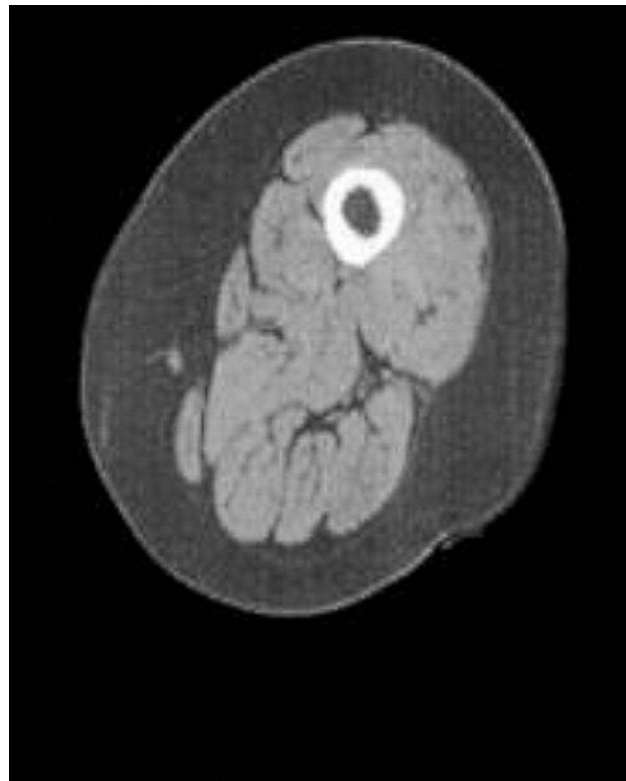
MRI of the same patient with moderate degree of obstruction, but evident sarcopenia. In the cross section of the subject's leg it is possible to notice a reduced muscle mass (light gray area), and a pronounced area of subcutaneous and intramuscular fat (dark gray area).
